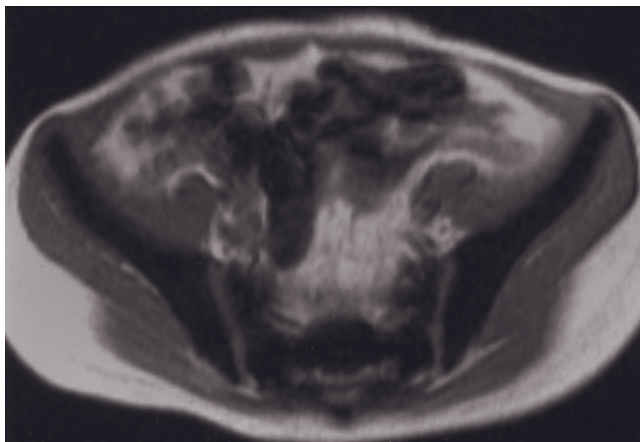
(Continued) T1-weighted (f) images, reflecting iron deposition. The spleen is enlarged and normal in signal intensity, reflecting that the patient has not required blood transfusion. Note the presence of two lesions in the spleen consistent with hemangiomas.
